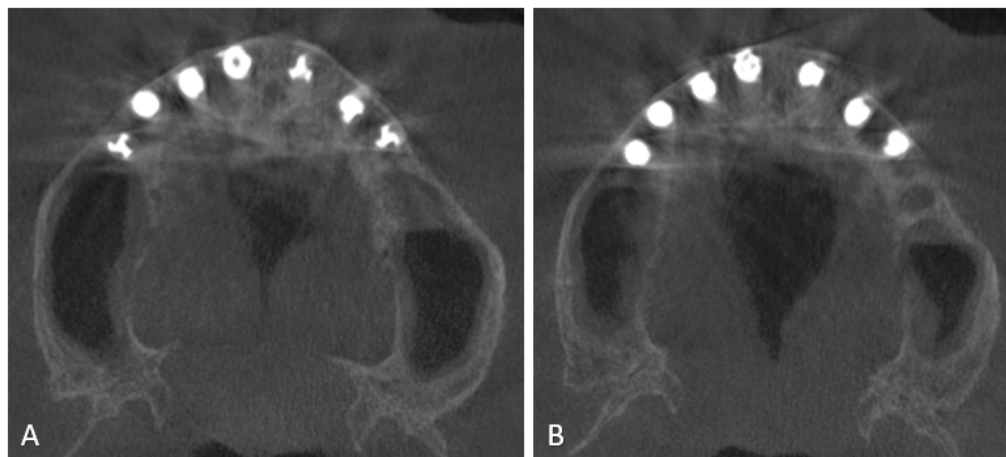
(A,B) CBCT slices of a seven-year follow-up after surgery.
